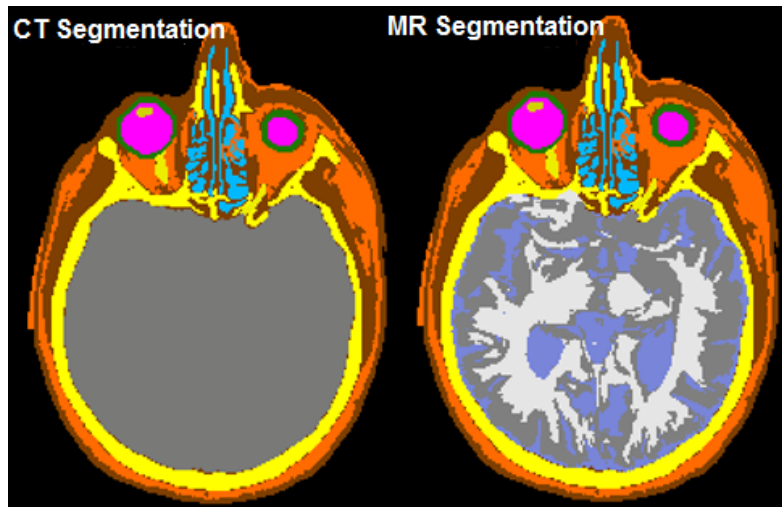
homogeneous (CT-based) versus detailed (MR-based) brain model, as used in this study to investigate the influence of brain segmentation details.
